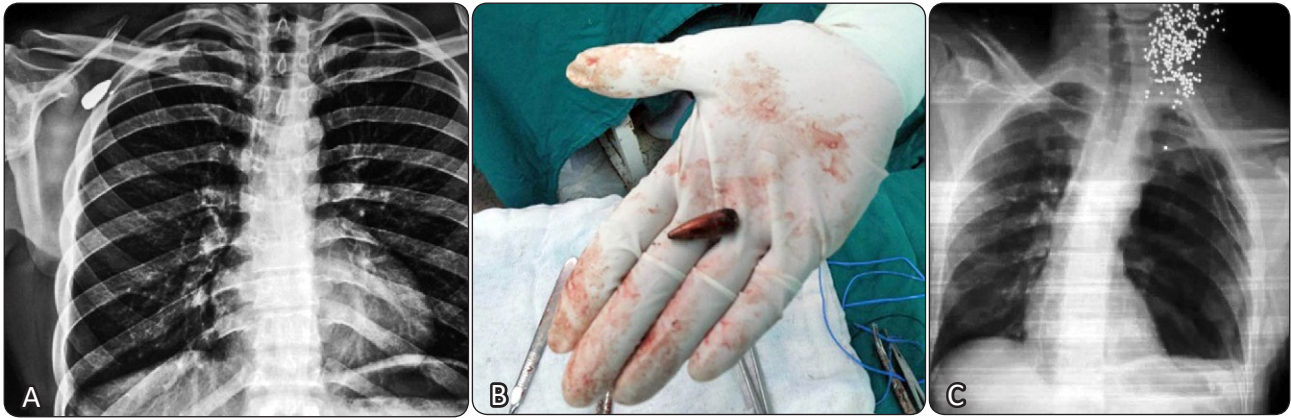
(A) Chest X-ray of one of our patients bullet injury (B) extracted bullet, (C) X-ray chest of another patient presented to the team with history of gunshot injury
